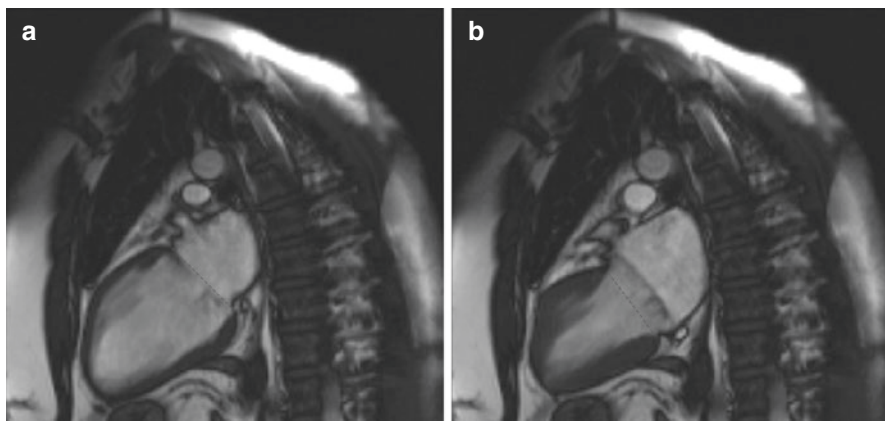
Cardiac magnetic resonance imaging assessment of the left ventricular ejection fraction in Barlow disease. Image (a) represents end-diastolic frame and image (b) represents end-systolic frame. The green dotted line marks the left ventricular cavity border with the left atrium for purposes of ejection fraction assessment. At end-systole, the volume of blood entrapped within the mitral valve leaflets is excluded from the end-systolic volume of the left ventricle
